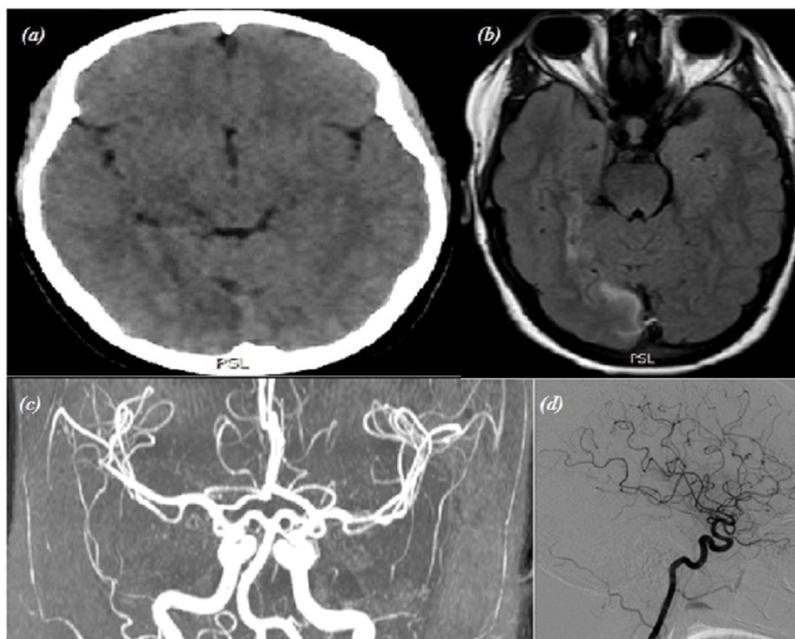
a) CT brain without contrast showing a cortical-subcortical hypodensity involving the right occipital and the right temporal lobes consistent with an ischemic infarct.
